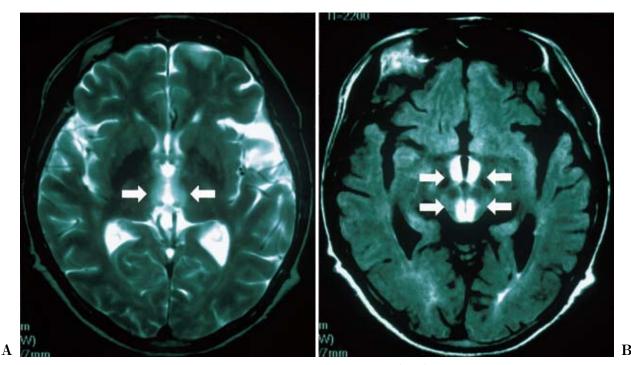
Brain magnetic resonance imaging (MRI) on admission.
